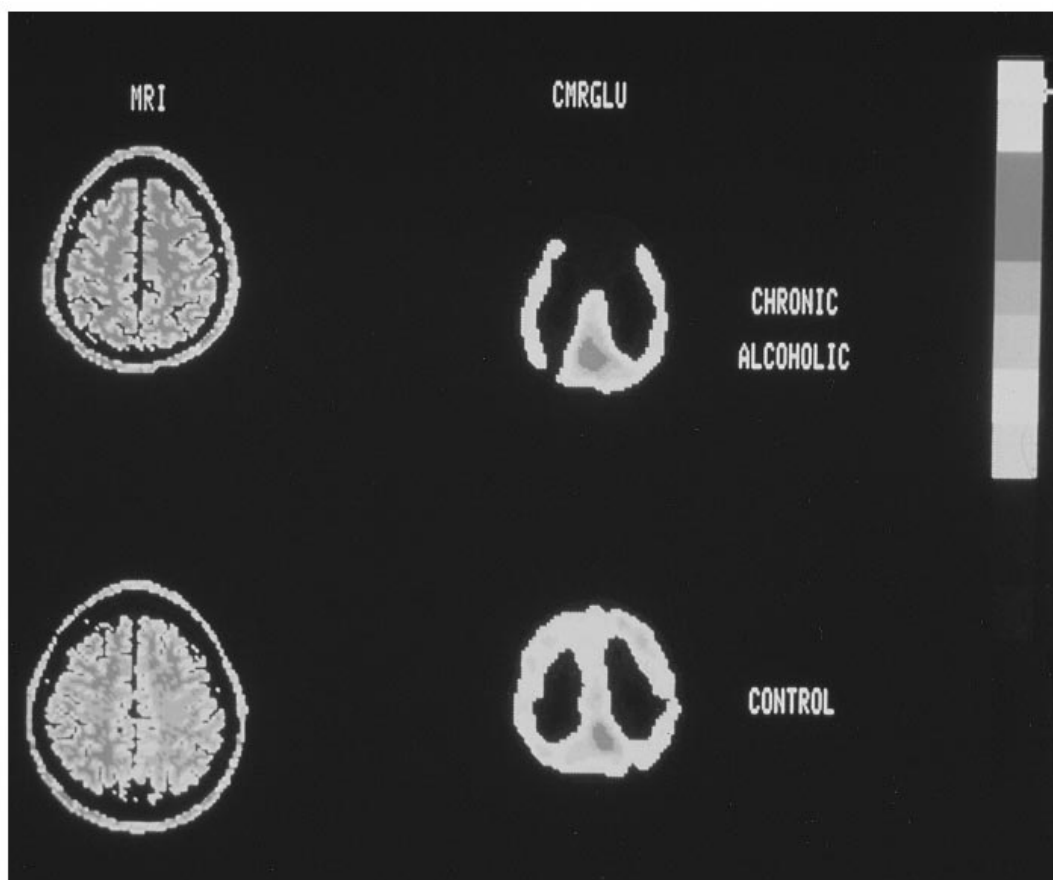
MRI and PET images in an alcoholic subject and a healthy volunteer. The mediofrontal hypometabolism is clearly visible on the PET image of the alcoholic patient, despite the very slight degree of cortical atrophy at MRI.
